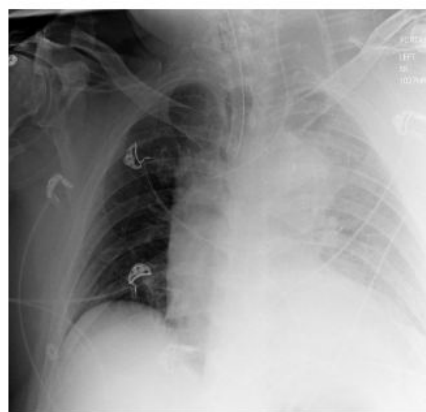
Left side hematoma on chest x-ray.
